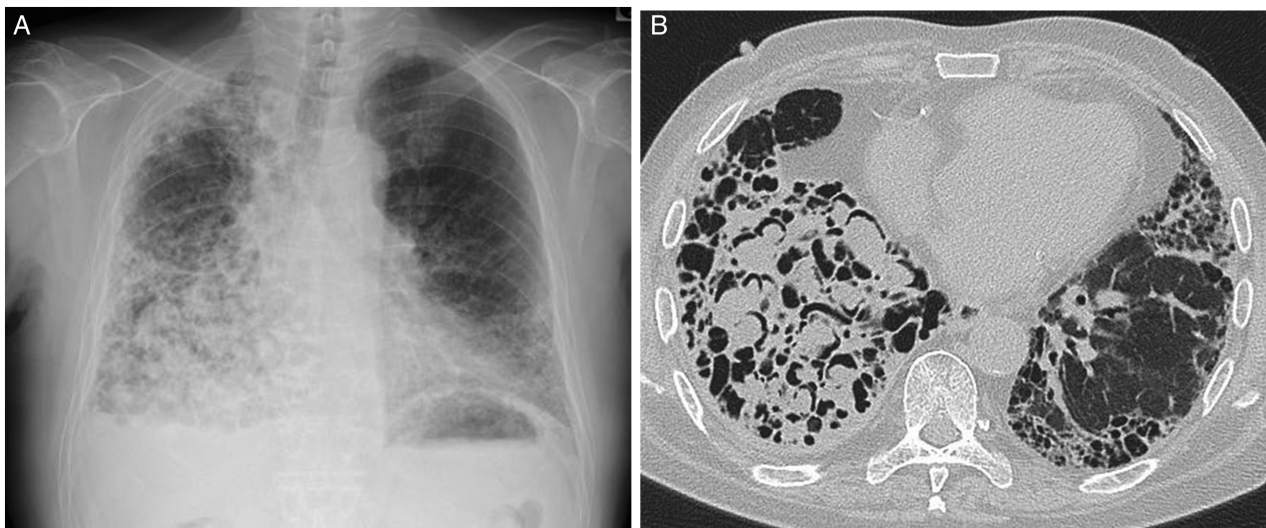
(A) Chest X-ray showed bilateral reticular opacities and multiple nodules in the right lung. (B) Chest computed tomography showed bilateral reticular opacities and honeycombing and multiple cavities with fungus balls within the right lower lobe.
